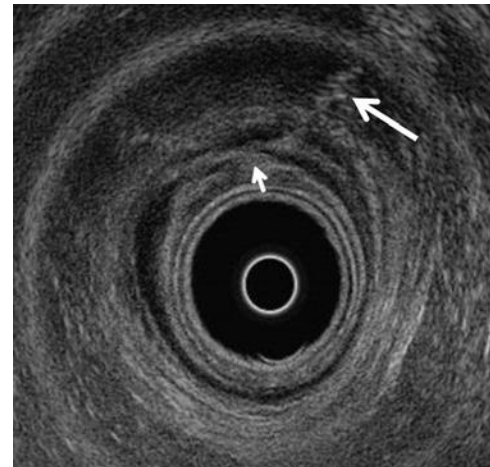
Fistula. Endorectal axial ultrasound image showing disruption of the anterior aspect of the external anal sphincter highlighted by echogenic air bubbles (long arrow). The fistula extends into the intersphincteric space but not through the hypoechoic internal anal sphincter (IAS). However, the IAS appears disrupted anteriorly at the 11 to 12 o'clock position (short arrow).
